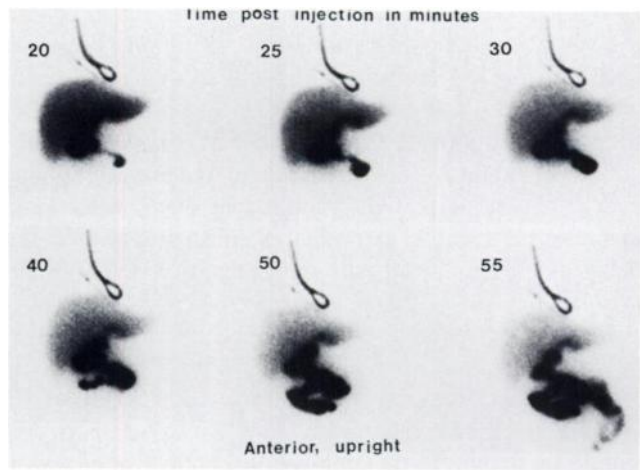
Repeat hepatobiliary scintigraphy performed with the patient in the upright position three days later. At 20 min postinjection, passage of the radionuclide into the Roux-en-Y limb is clearly seen. With the patient remaining in the upright position, there is evidence of good and prompt biliary flow into the intestine between 25–55 min. The significant accumulation of the radionuclide in the region of anastomosis seen on the initial supine study is no longer noted.
